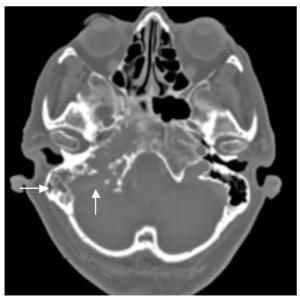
Axial computed tomography scan showing the extensive destruction of the right temporal bone (arrows).
